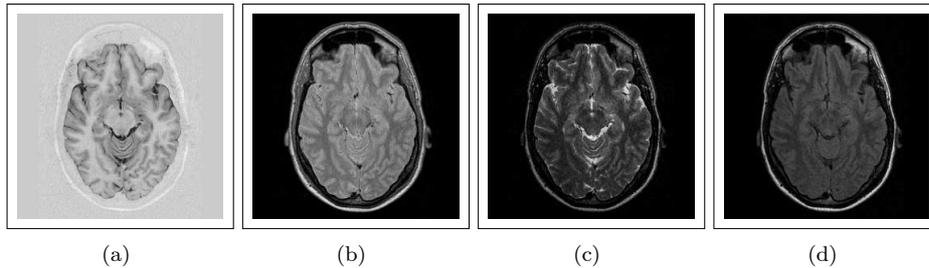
Image Sequences : (a) IRTSE (b) VE(PD) (c) VE(T2) (d) FLAIR
